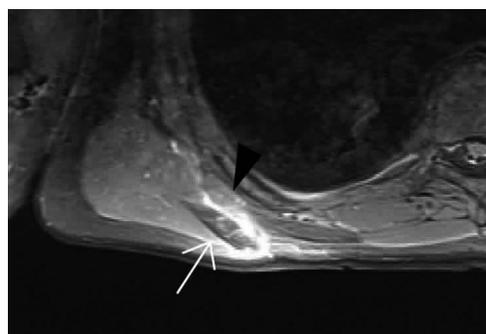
A T2-weighted magnetic resonance image showing focal fluid collection at the anatomic insertion region of the retracted serratus anterior muscle (black arrowhead) at the inferior angle of the scapula (white arrow).
